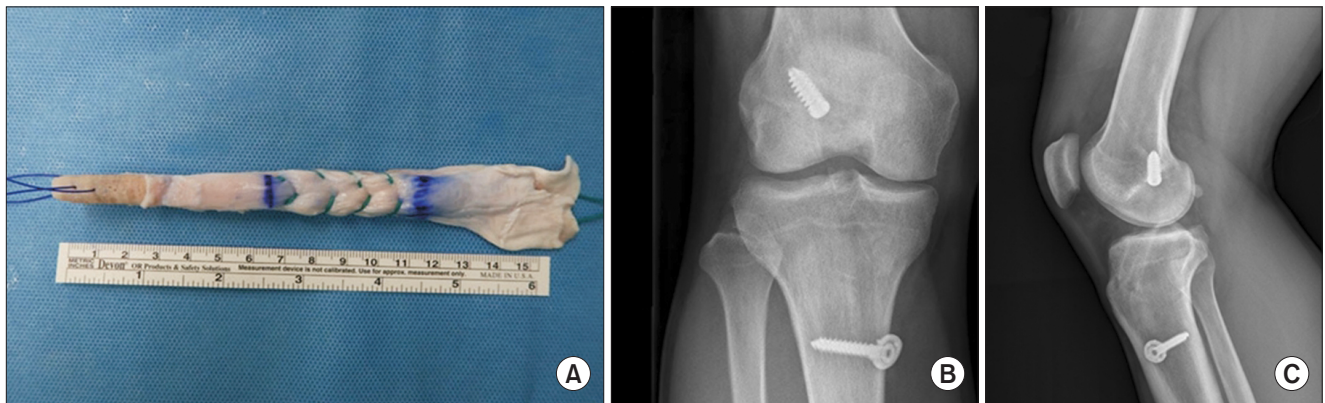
Intraoperative gross photo of a quadriceps tendon-patellar bone allograft (A) and postoperative anteroposterior (B) and lateral (C) simple radiographs of a study patient.
